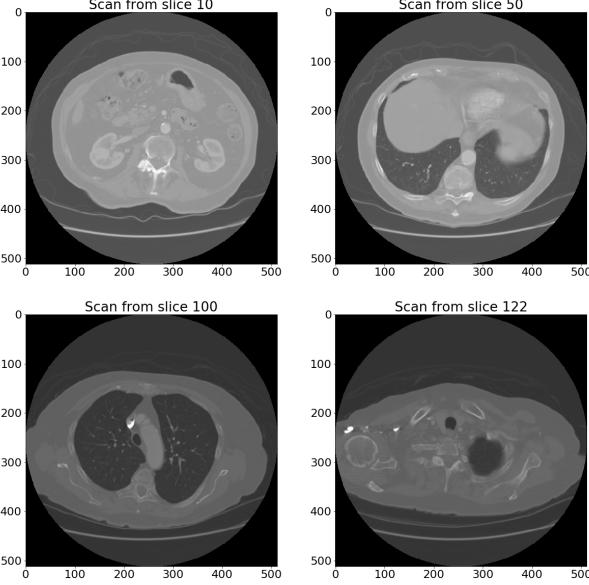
Scan from different locations in a CT scan for a patient
